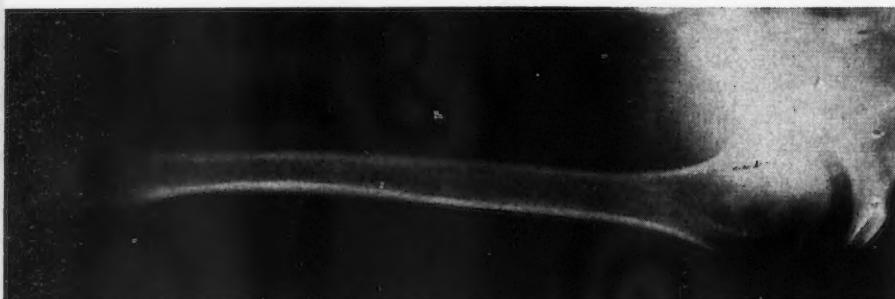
Left humerus from a man aged 37 years with severe muscular dystrophy of 20 years' duration, showing osteoporosis most marked at the bone ends and thinning of the cortex. For comparison with other radiographs reproduced in this paper.
